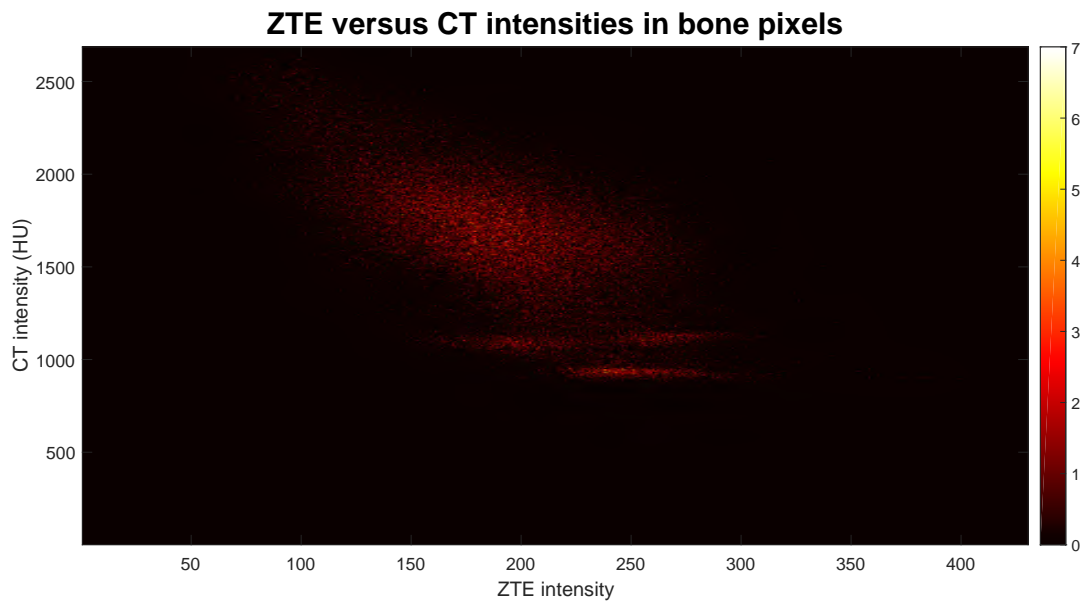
Joint histogram for bone pixels in ZTE and CT images.
